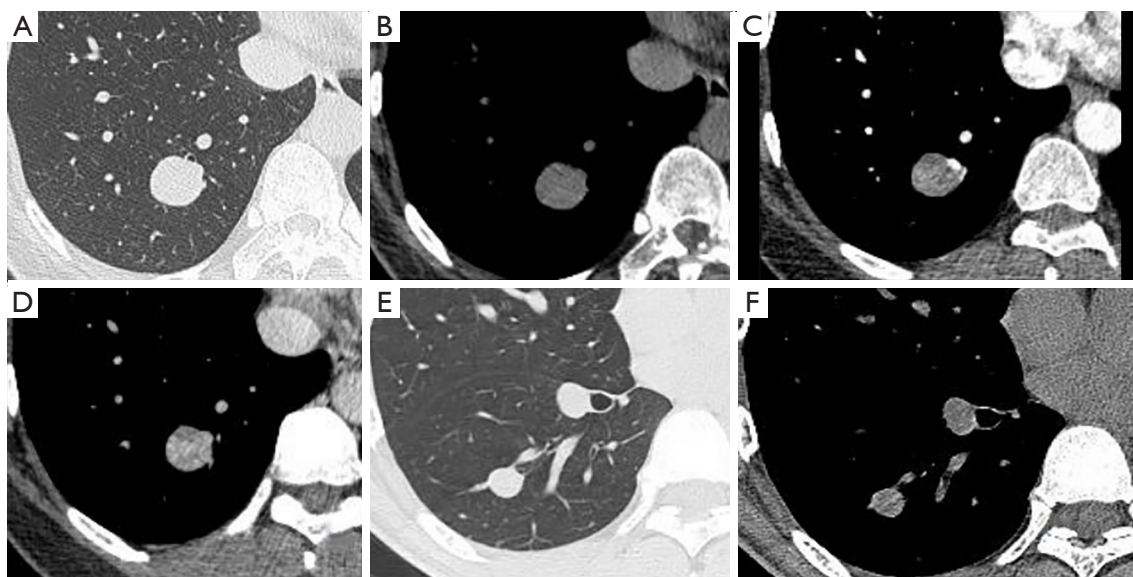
Images from Cases 1 (A-D: chest CT scan) and 2 (E,F: chest CT scan). Case 1: A 42-year-old female with nodules in right lower lobe identified in physical examination. (A-D) Chest CT nonenhanced and enhanced scans. (A) Lung window: quasicircular nodules, approximately 19 mm in diameter, observed in the posterior basal segment of the right lower lobe. (B) Mediastinum window: nodules of even density, with a CT attenuation value of about 26 HU. (C,D) Enhanced scan: mild enhancement during the arterial phase, with a CT attenuation value of about 37 HU; uneven enhancement during the venous phase, with a CT attenuation value of about 4–133 HU and a blood vessel running along the margin of the lesion. Case 2: A 23-year-old male with nodules in the right lower lobe identified in physical examination. (E,F) Chest CT scans. (E) Lung window: quasicircular nodules, approximately 15 mm in diameter, observed in the dorsal segment of the right lower lobe. (F) Mediastinum window: nodules of even density, and a CT attenuation value about 27 HU. CT, computed tomography; HU, Hounsfield units.
